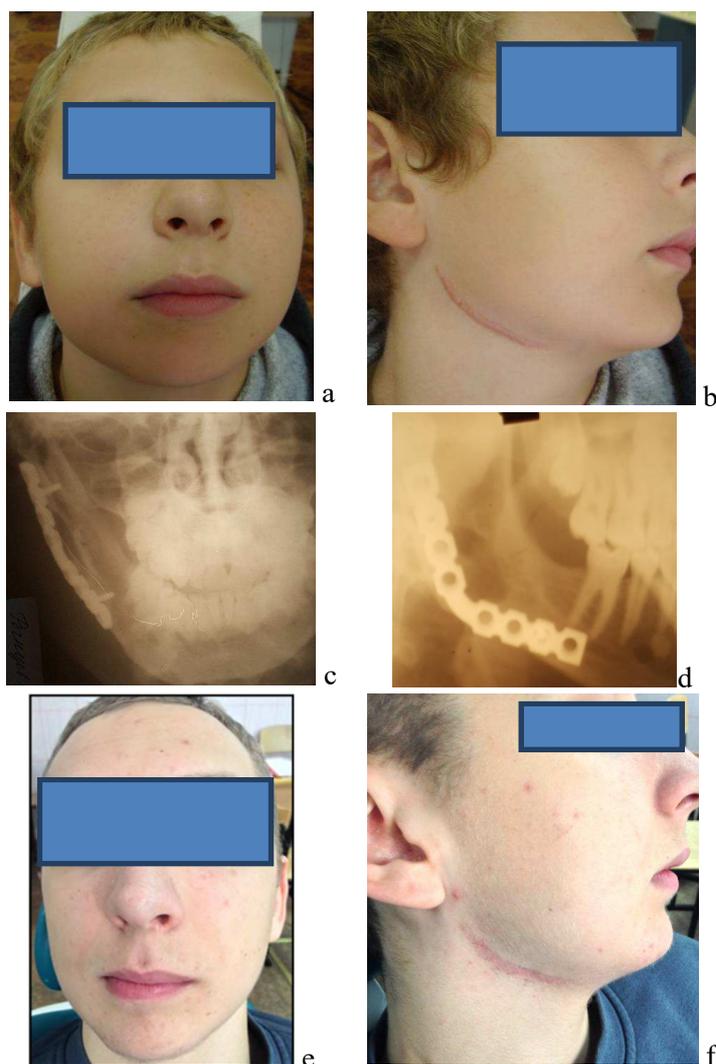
General view of the child's face (a, b) and radiographs (c, d) 1 year after the surgery of AB on the right mandible (c, d – reconstructive titanium plate is observed) and general appearance of the face of the same child 7 years after AB resection (facial asymmetry and postoperative scar in the submandibular area are determined)
